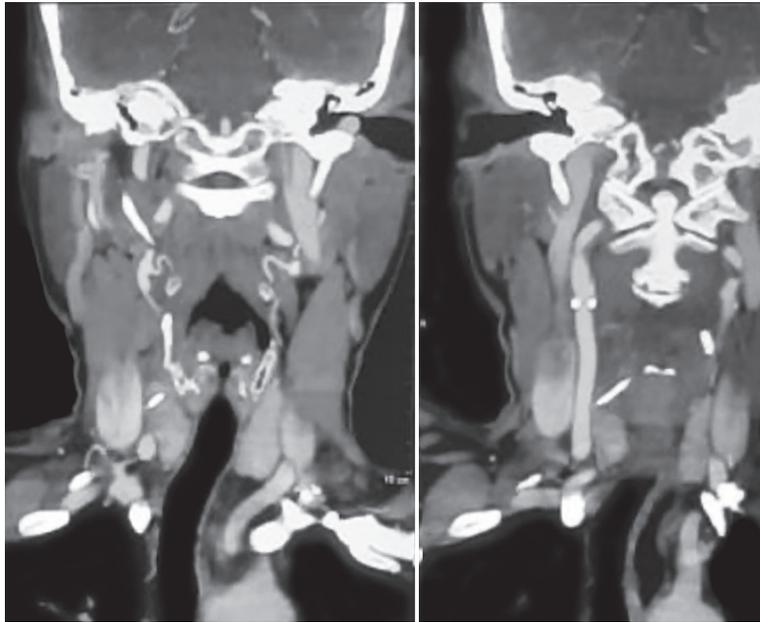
Contrast-enhanced computed tomography neck showing a foreign body
